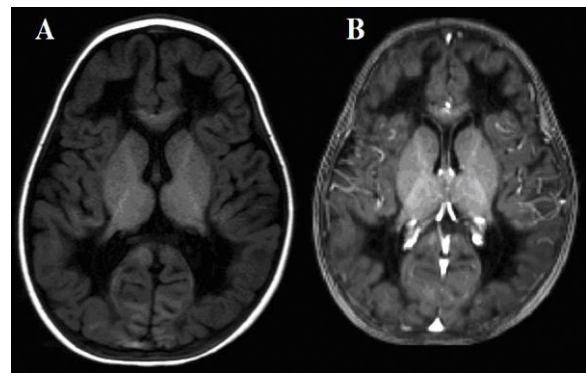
T1-weighted pre (A) and post (B) contrast magnetic resonance images respectively, with axial sections at basal ganglia; shows diffuse white matter hypointensity and no abnormal contrast enhancement.
